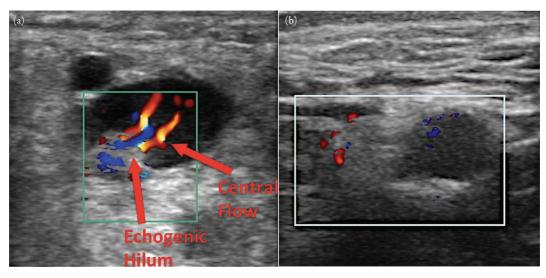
(a) Reactive lymph node. Long axis view of a reactive lymph node with echogenic center and evidence of central flow on color Doppler. (b) Malignant lymph node. Long axis view of a malignant lymph node. This can be distinguished as a malignant lymph node because it is more round with S:L ratio >0.5cm and does not have an echogenic center. Also, it has a small amount of peripheral blood flow unlike normal and reactive lymph nodes, which tend to have more central blood flow.
